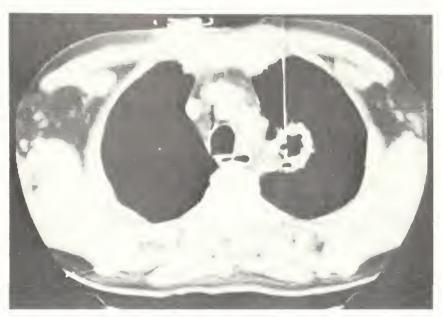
CT scan of a left upper lobe cavitary lung lesion with E-Z-EM needle in place.
